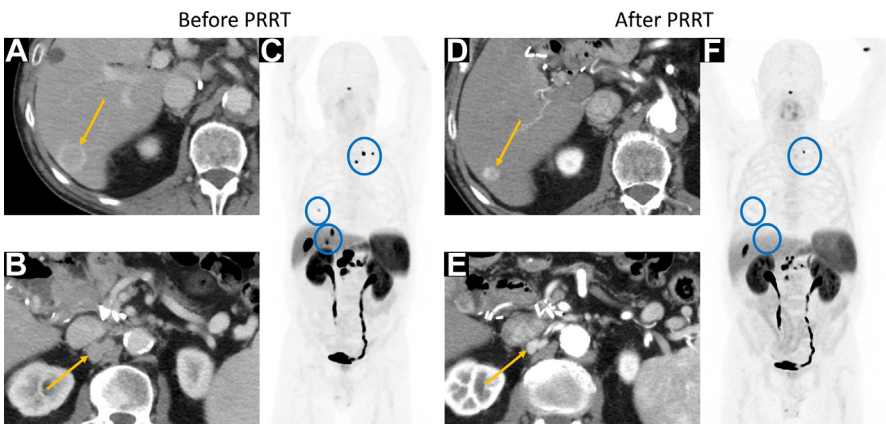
Patient with G1 metastatic PNET treated with PRRT. Pretherapy contrast-enhanced abdominal CT (A, B) and ^{68}Ga -DOTATATE PET (C) show liver, retroperitoneal, and osseous metastases (arrows). Post-4 cycles of PRRT, decreased size of the liver metastases and retroperitoneal nodes on CT (D, E) (arrows), and resolution of several osseous and liver metastases on ^{64}Cu -DOTATATE PET (F) (blue circles). Findings consistent with disease response.
